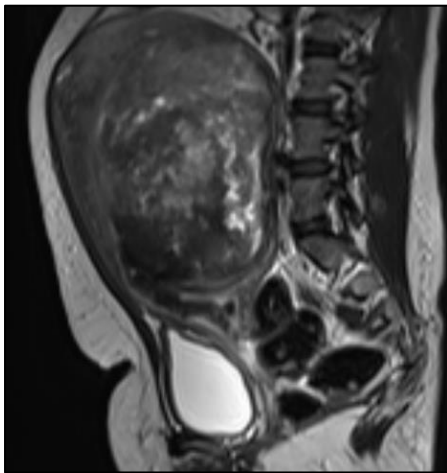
MRI image with a large atypical uterine fibroid showing cystic and degenerative changes, with prolapsed submucosal component in the endocervical canal.
